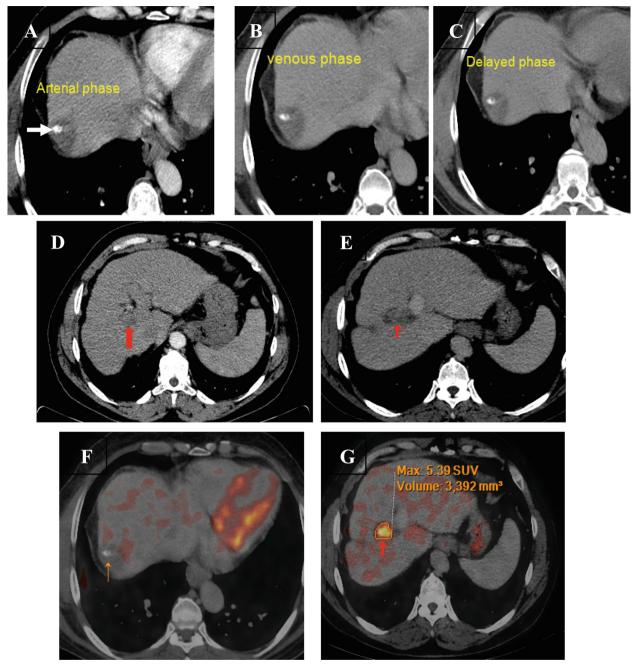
a–c CECT phases show hypo dense hepatic dome focal lesion with dispersed lipiodol droplet at its centre with no contrast enchantment detected (arrow). d and e Axial CTEC shows portal vein thrombus (red arrow), not enhancing at the arterial phase. F Axial fused PET/CT image shows hyper metabolic portal vein thrombus denoting tumoral thrombus other than benign PV thrombus in spite of being not enhancing at the arterial phase (q).
